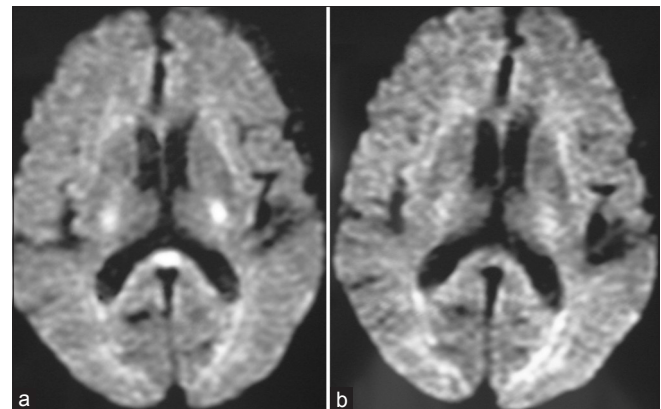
(a) Oval-shaped high signal intensity was detected in the splenium of the corpus callosum on diffusion-weighted MRI (b) The lesion had disappeared on MRI on the next day with the recovery from hypoglycemia
